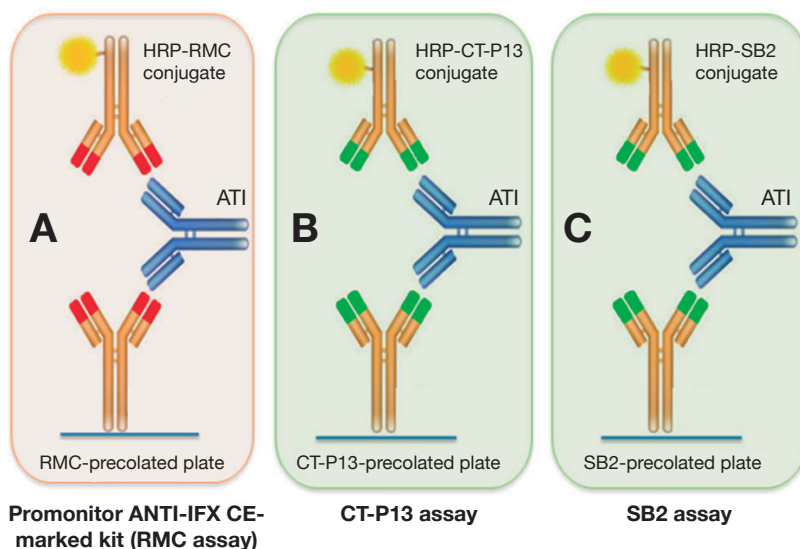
Three enzyme-linked immunosorbent assays for detecting antidrug antibodies reacting with reference infliximab, CT-P13 and SB2 [17,18]. ANTI-IFX, anti-infliximab; ATI, antibodies to infliximab; CE, Conformité Européene; HRP, horseradish peroxidase; RMC, Remicade®.
